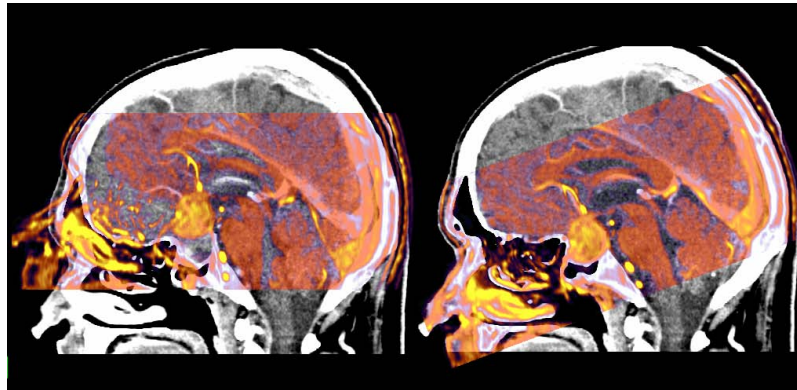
Registration: The CT and the MRA data are aligned; Left: CT and MRA images before the alignment; Right: after the alignment
